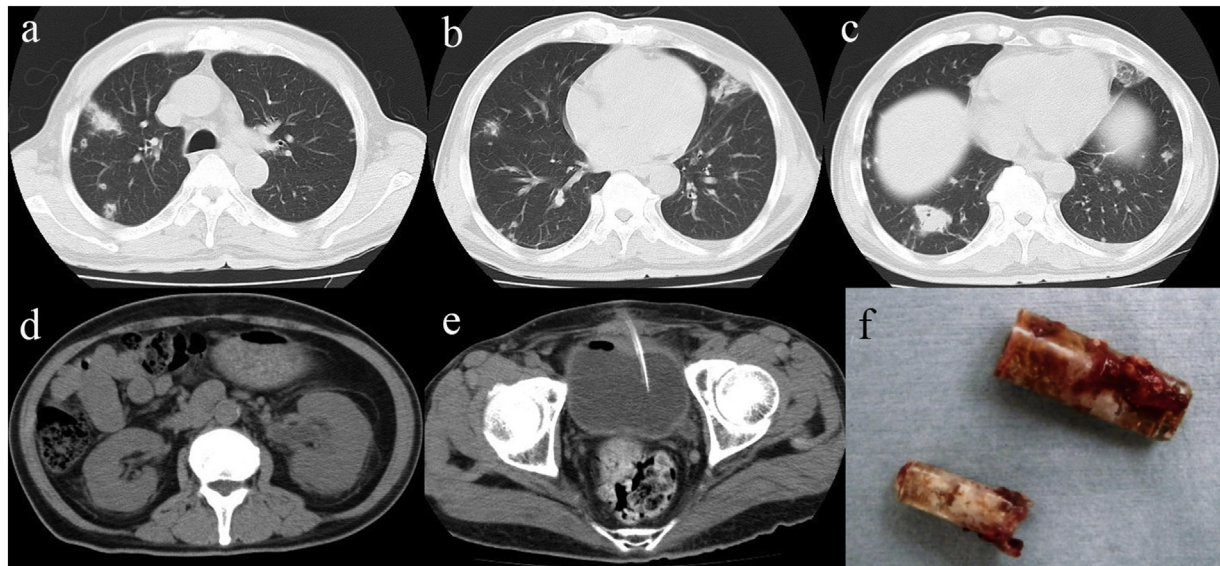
Images of chest and abdomen CT on day 12 and foreign bodies after extraction. Multiple nodular shadows were observed bilaterally in the lungs (a-c). After percutaneous cystostomy, the renal findings remained unchanged, and there was a large amount of urine retention in the bladder (d, e). Urethral foreign body findings: two cylindrical foreign bodies with the appearance of a smoking cessation pipe like plastics were extracted (f).
